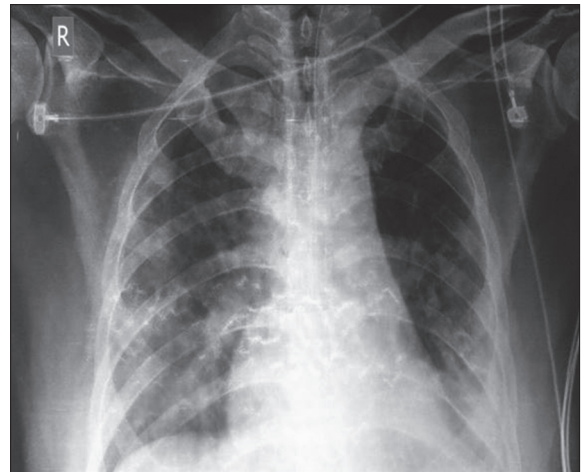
Initial chest X-ray showing bilateral infiltrate
